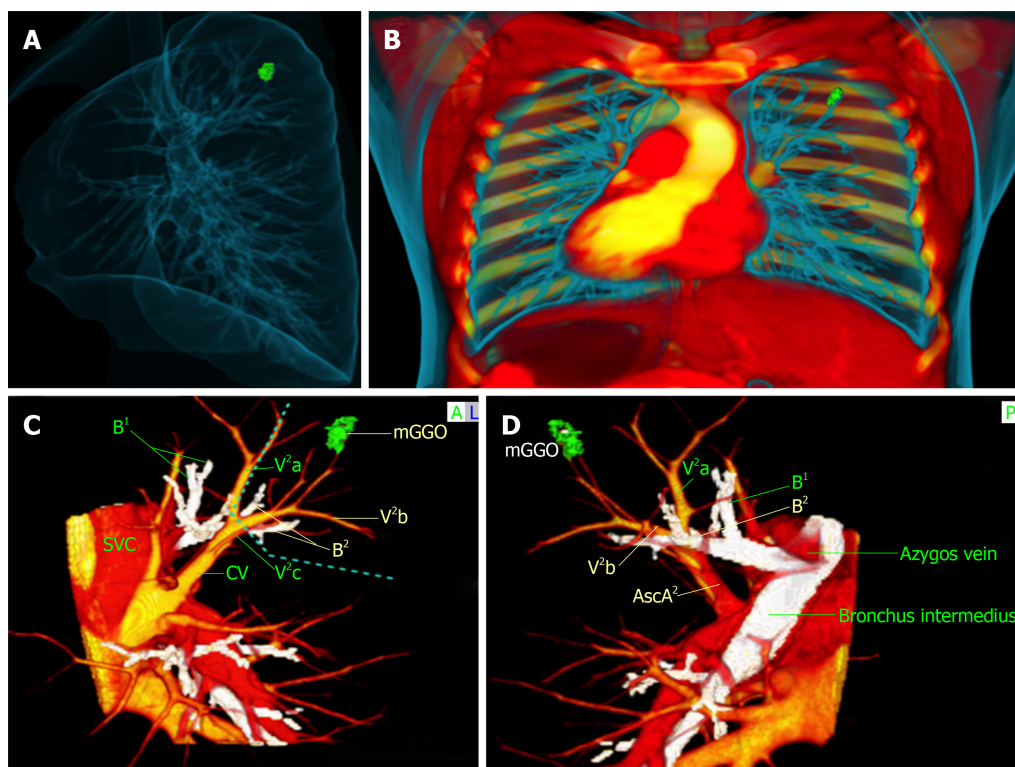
Three-dimensional images reconstructed with OsiriX software. A and B: Three-dimensional structure and spatial relation of bronchi and blood vessels; C and D: Exact three-dimensional computed tomography bronchography and angiography relationships between the mixed ground-glass opacity (mGGO) lesion and pulmonary anatomical structures. Green: The mGGO lesion; Yellow: Pulmonary veins; Red: Pulmonary artery; White: Bronchus. The blue dotted line denotes the safety margin. 3D-CTBA: Three-dimensional computed tomography bronchography and angiography; mGGO: Mixed ground-glass opacity.
